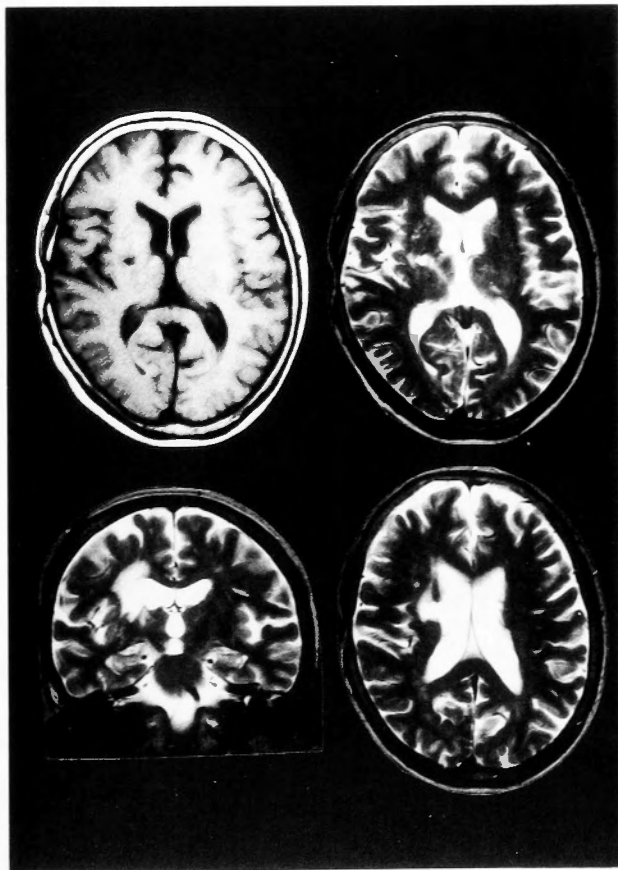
MRI showed ischemic lesion of the left thalamus in addition to the right lentiform nucleus and right corona radiata. Axial T1 weighted image (upper left), axial T2 weighted (T2W) images (upper right and lower right) and coronal T2W (lower left) image.
